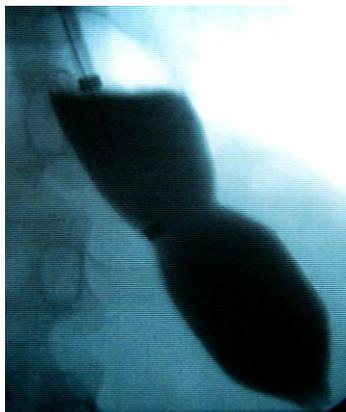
presents an X-ray picture of hydro balloon dilator at the time of extension (a water-soluble contrast Urografin 76%, 60 ml is injected). One can clearly see the dilator "waist" located in the zone of the spasmed cardia.
